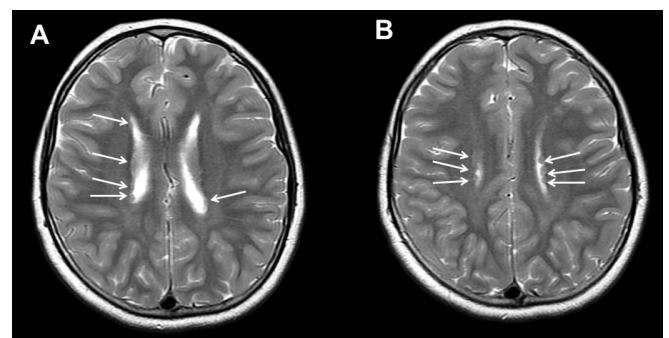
Brain T2-weighted axial magnetic resonance imaging. (A, B) Small nodular lesions (arrows) isointense with gray matter appeared lining the lateral wall of both lateral ventricles, which indicates subependymal gray-matter heterotopia.
